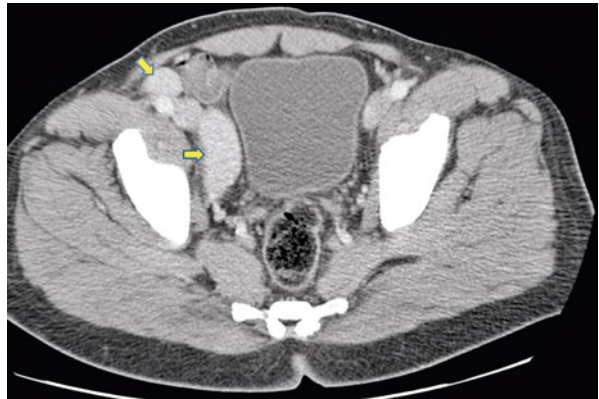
Kaposi's sarcoma. Axial CT image shows diffuse soft tissue edema. There are enhancing bilateral obturator lymph nodes (arrows)
